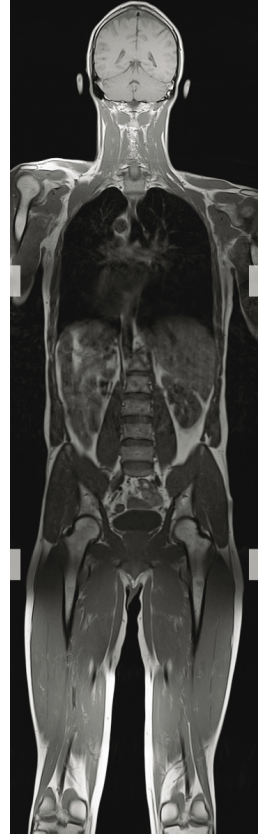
WB-MRI from 3 stations. Gray bars show overlap.
